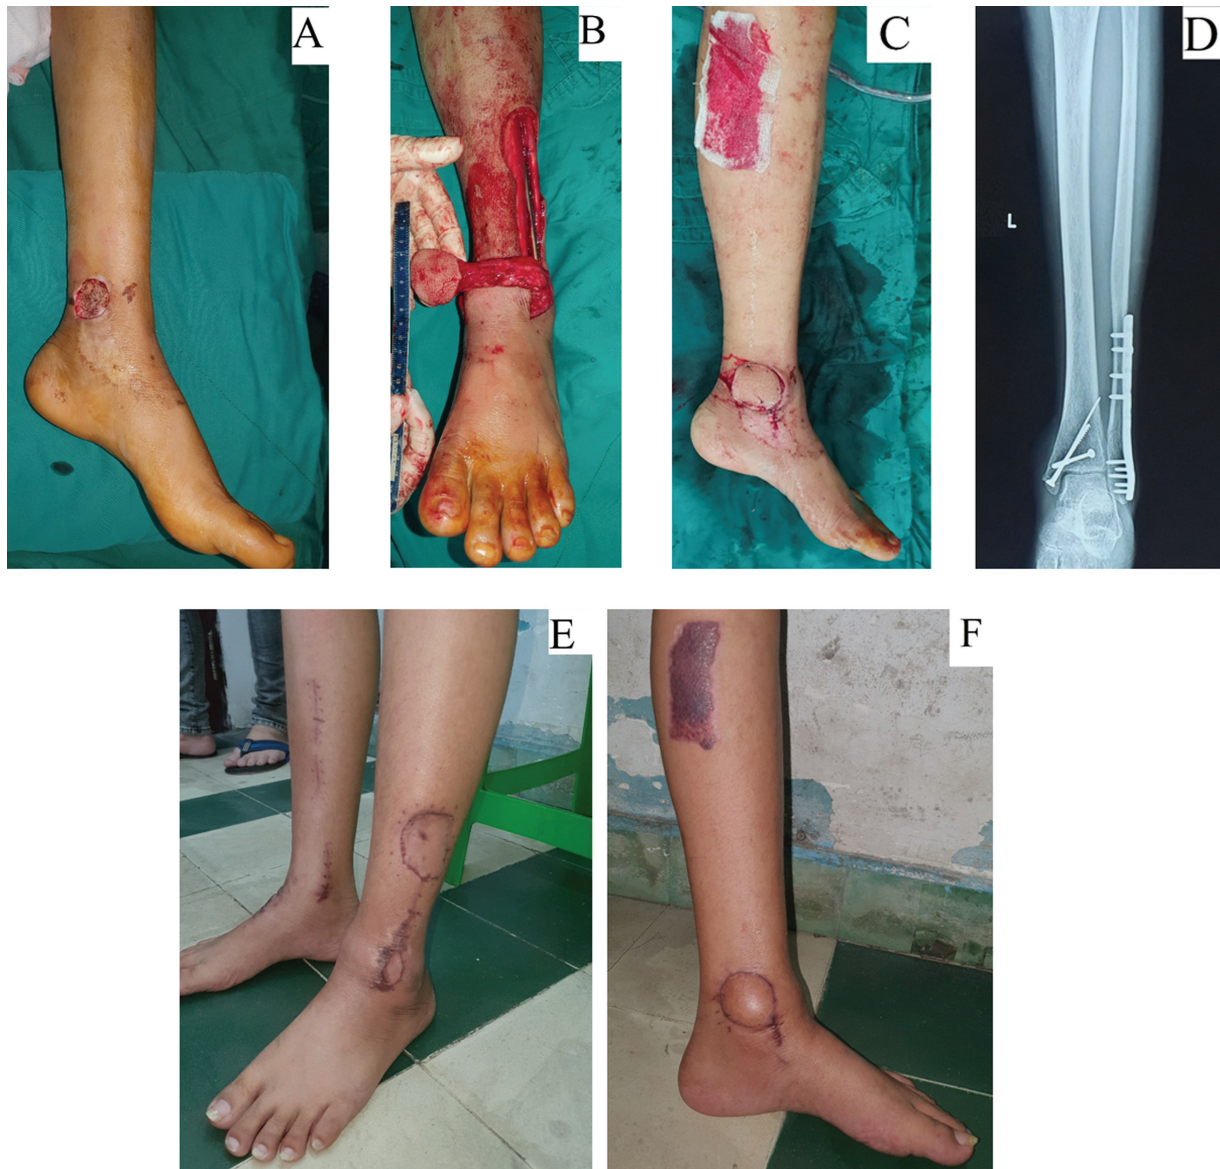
Combined flap dissection with bone fixation in one procedure. (A) Expose medial malleolus fracture. (B) Bone fixation by plate and flap elevation. (C) Closing the wound by retrograde lateral supramalleolar (LSM) flap. (D) X-ray image of bone fixation. (E) Donor site healing by a skin graft. (F) Flap healing.
